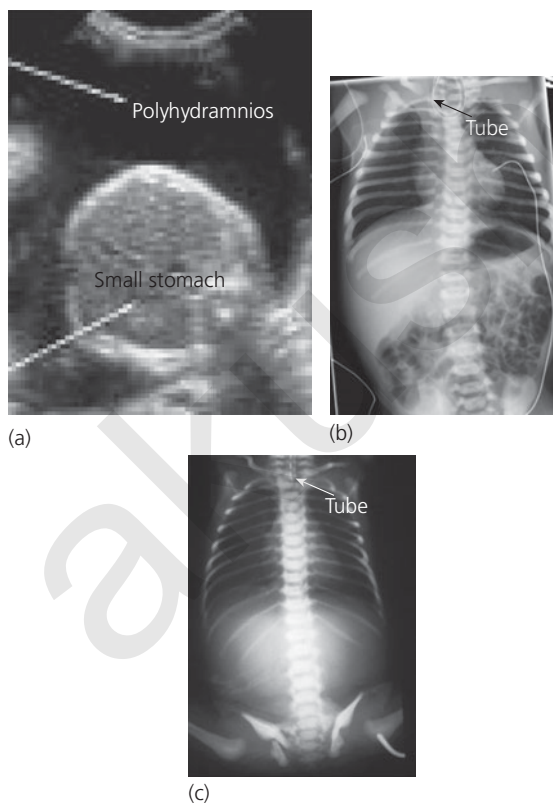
(a) Prenatal imaging of suspected tracheo-esophageal (TOF) with polyhydramnios and small stomach. (b) Plain radiograph showing esophageal pouch tube and distal gas confirming TOF with esophageal atresia. (c) Plain radiograph showing esophageal pouch tube and no abdominal gas confirming isolated esophageal atresia.
